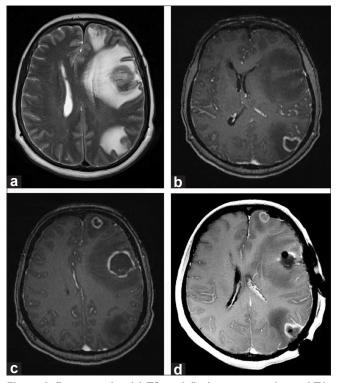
Pre-operative (a) T2, and (b,c) contrast-enhanced T1weighted MRI demonstrating three ring-enhancing lesions with significant perilesional edema. (d) Postoperative contrast-enhanced T1-weighted MRI demonstrating postoperative changes from biopsy of the left parietal-occipital and left frontal lesions
